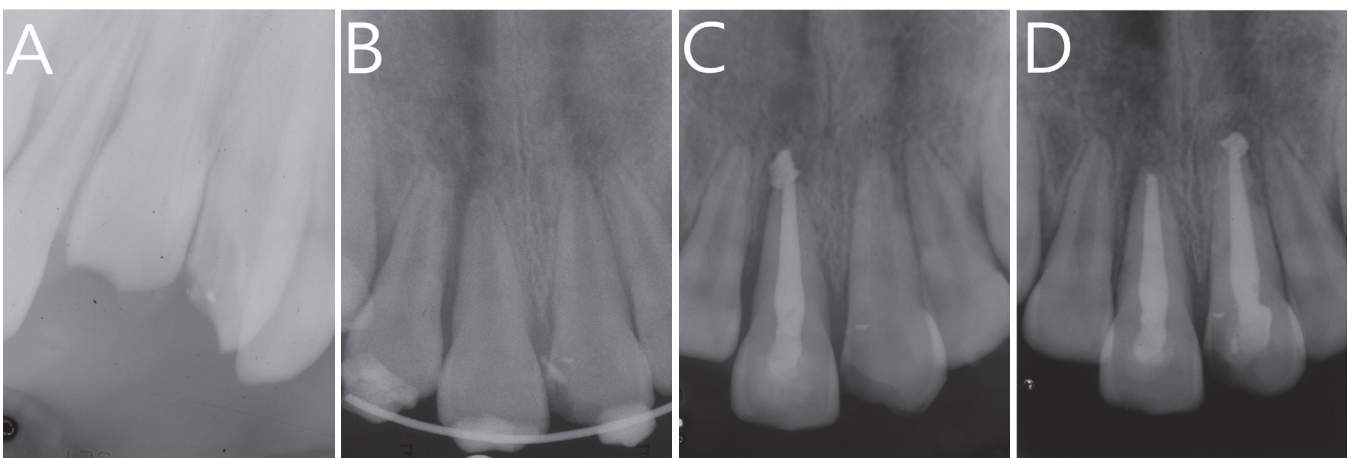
Periapical radiographs of root fractures. (A) Initial periapical view. (B) Reduction and wire-splinted root-fractured tooth. (C) Pulp extirpation and calcium hydroxide canal filling were performed. (D) 2-month follow-up.
